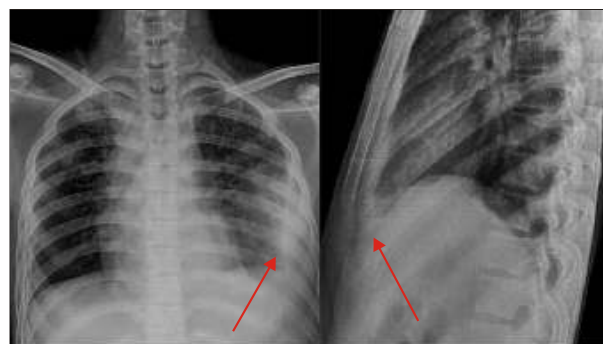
Chest X-ray (AP view) suggestive of right paratracheal stripe widening. There is loculated collection noted in left pleural cavity with blunting of left costo-phrenic angles/o pleural effusion.
